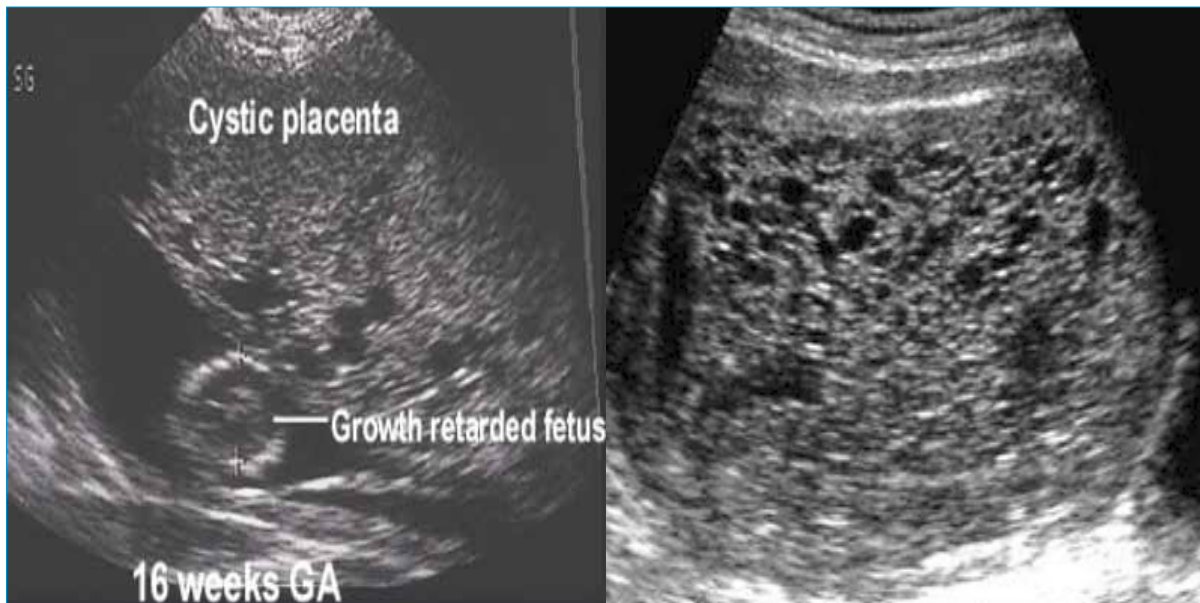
Transabdominal Ultrasound image of Molar pregnancy Left: partial showing a growth restricted fetus (BPD measure 12 weeks but the pregnancy is 16 weeks) and molar placenta. and Right: complete mole showing the typical appearance of bulky uterus filled with a mixed echogenic mass. Multiple tiny anechoic cystic spaces are seen in the uterine cavity giving the picture of “snow storm” appearance.
